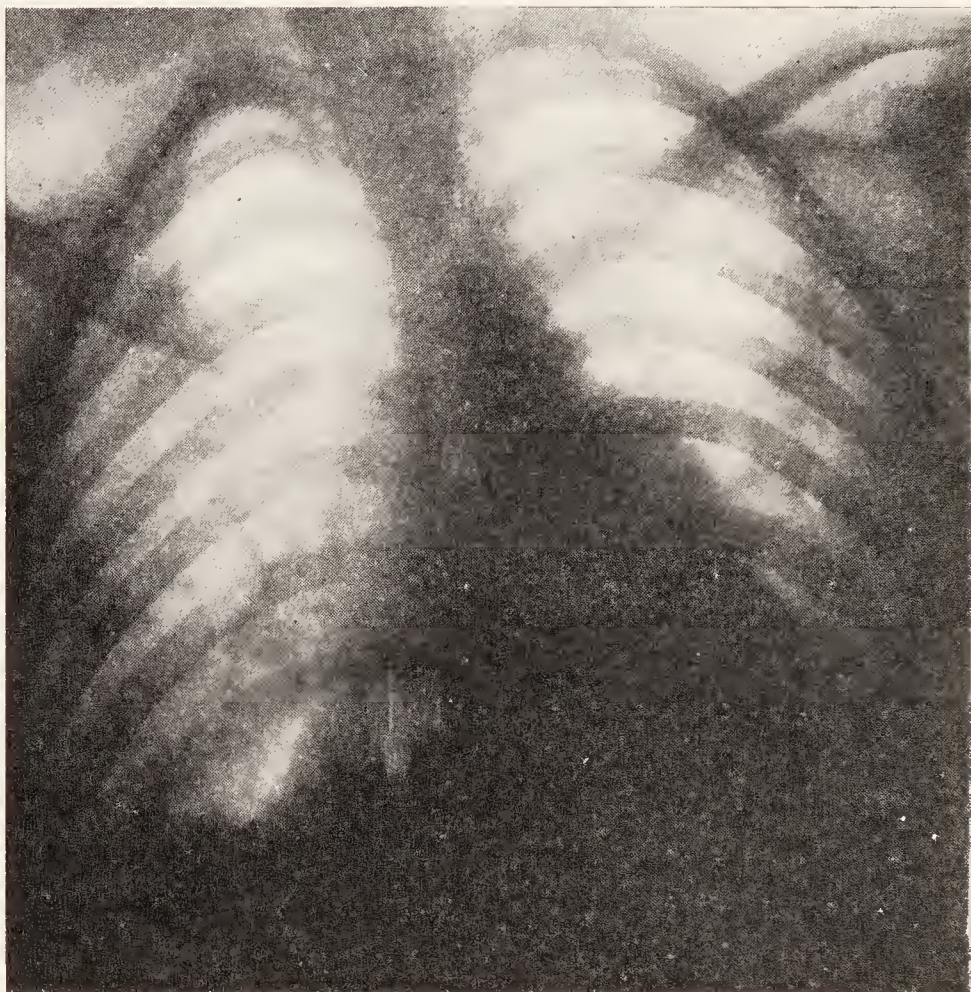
Necropsy 4152. The same, one month before death. Heart shadow still roughly triangular and distinctly abnormal. (Roentgenological Department, Massachusetts General Hospital.)
